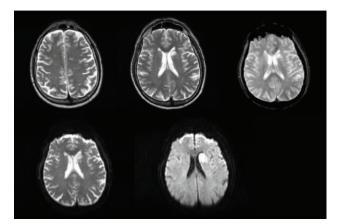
Brain MRI – Day 2 of presentation. The Images demonstrate multiple foci of recent infarction in the supratentorial and tentorial brain; and no evidence of intracranial hemorrhage.
